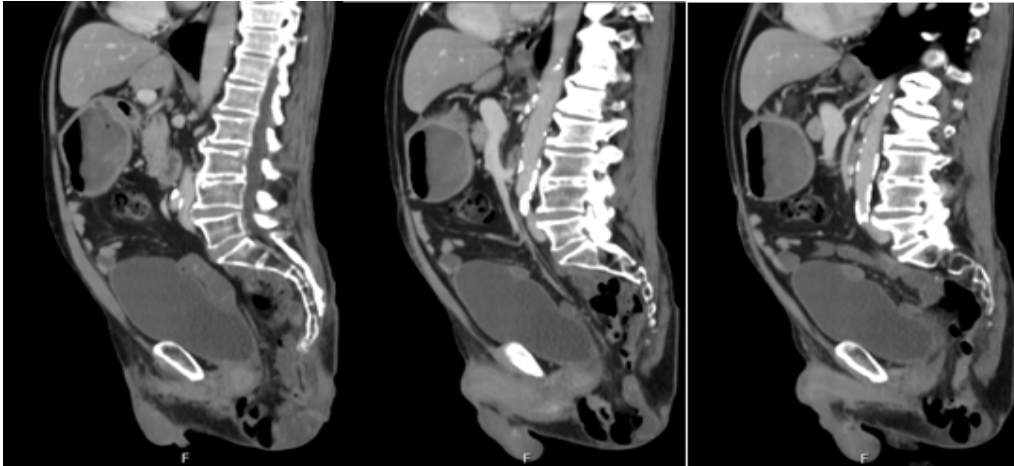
CT-scan (sagittal) revealing a perineal hernia at the level of the posterior pelvic floor.
